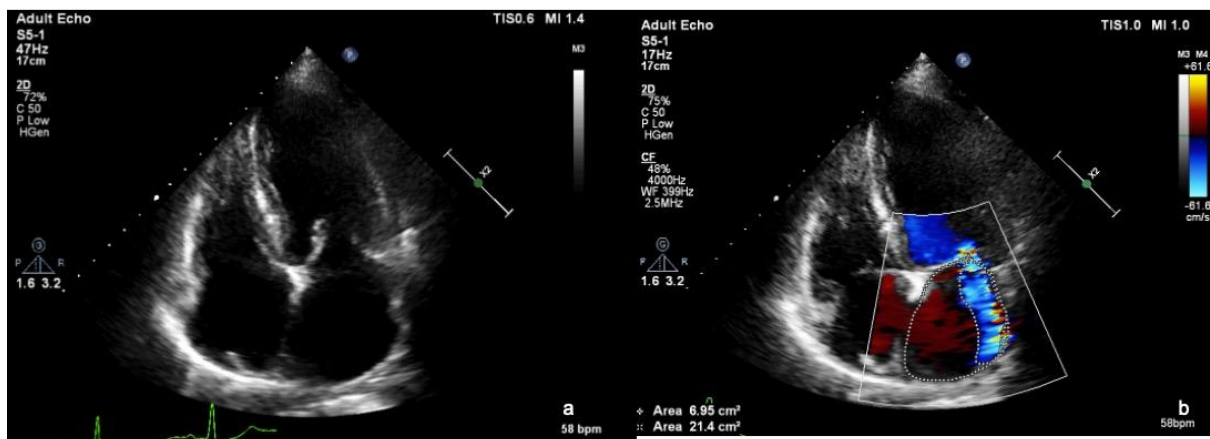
Echocardiogram images showing mild mitral regurgitation (post revascularization).
